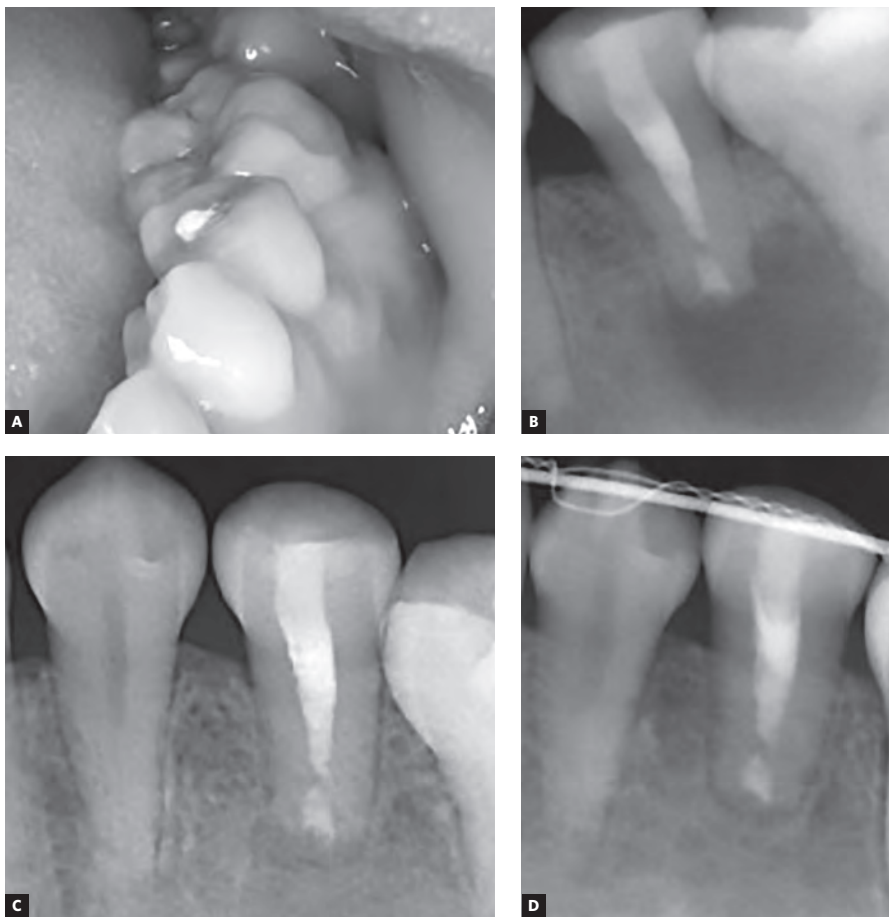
A) Photograph 15 days after the surgery where no signs of the fistula can be seen. B) Radiograph of #3.5 after the final coronal filling. C) Periapical radiography of #3.5 six months after the periapical surgery and removal of the periapical cyst. D) Periapical radiography of #3.5 twelve months later. The patient had begun the orthodontic treatment.
